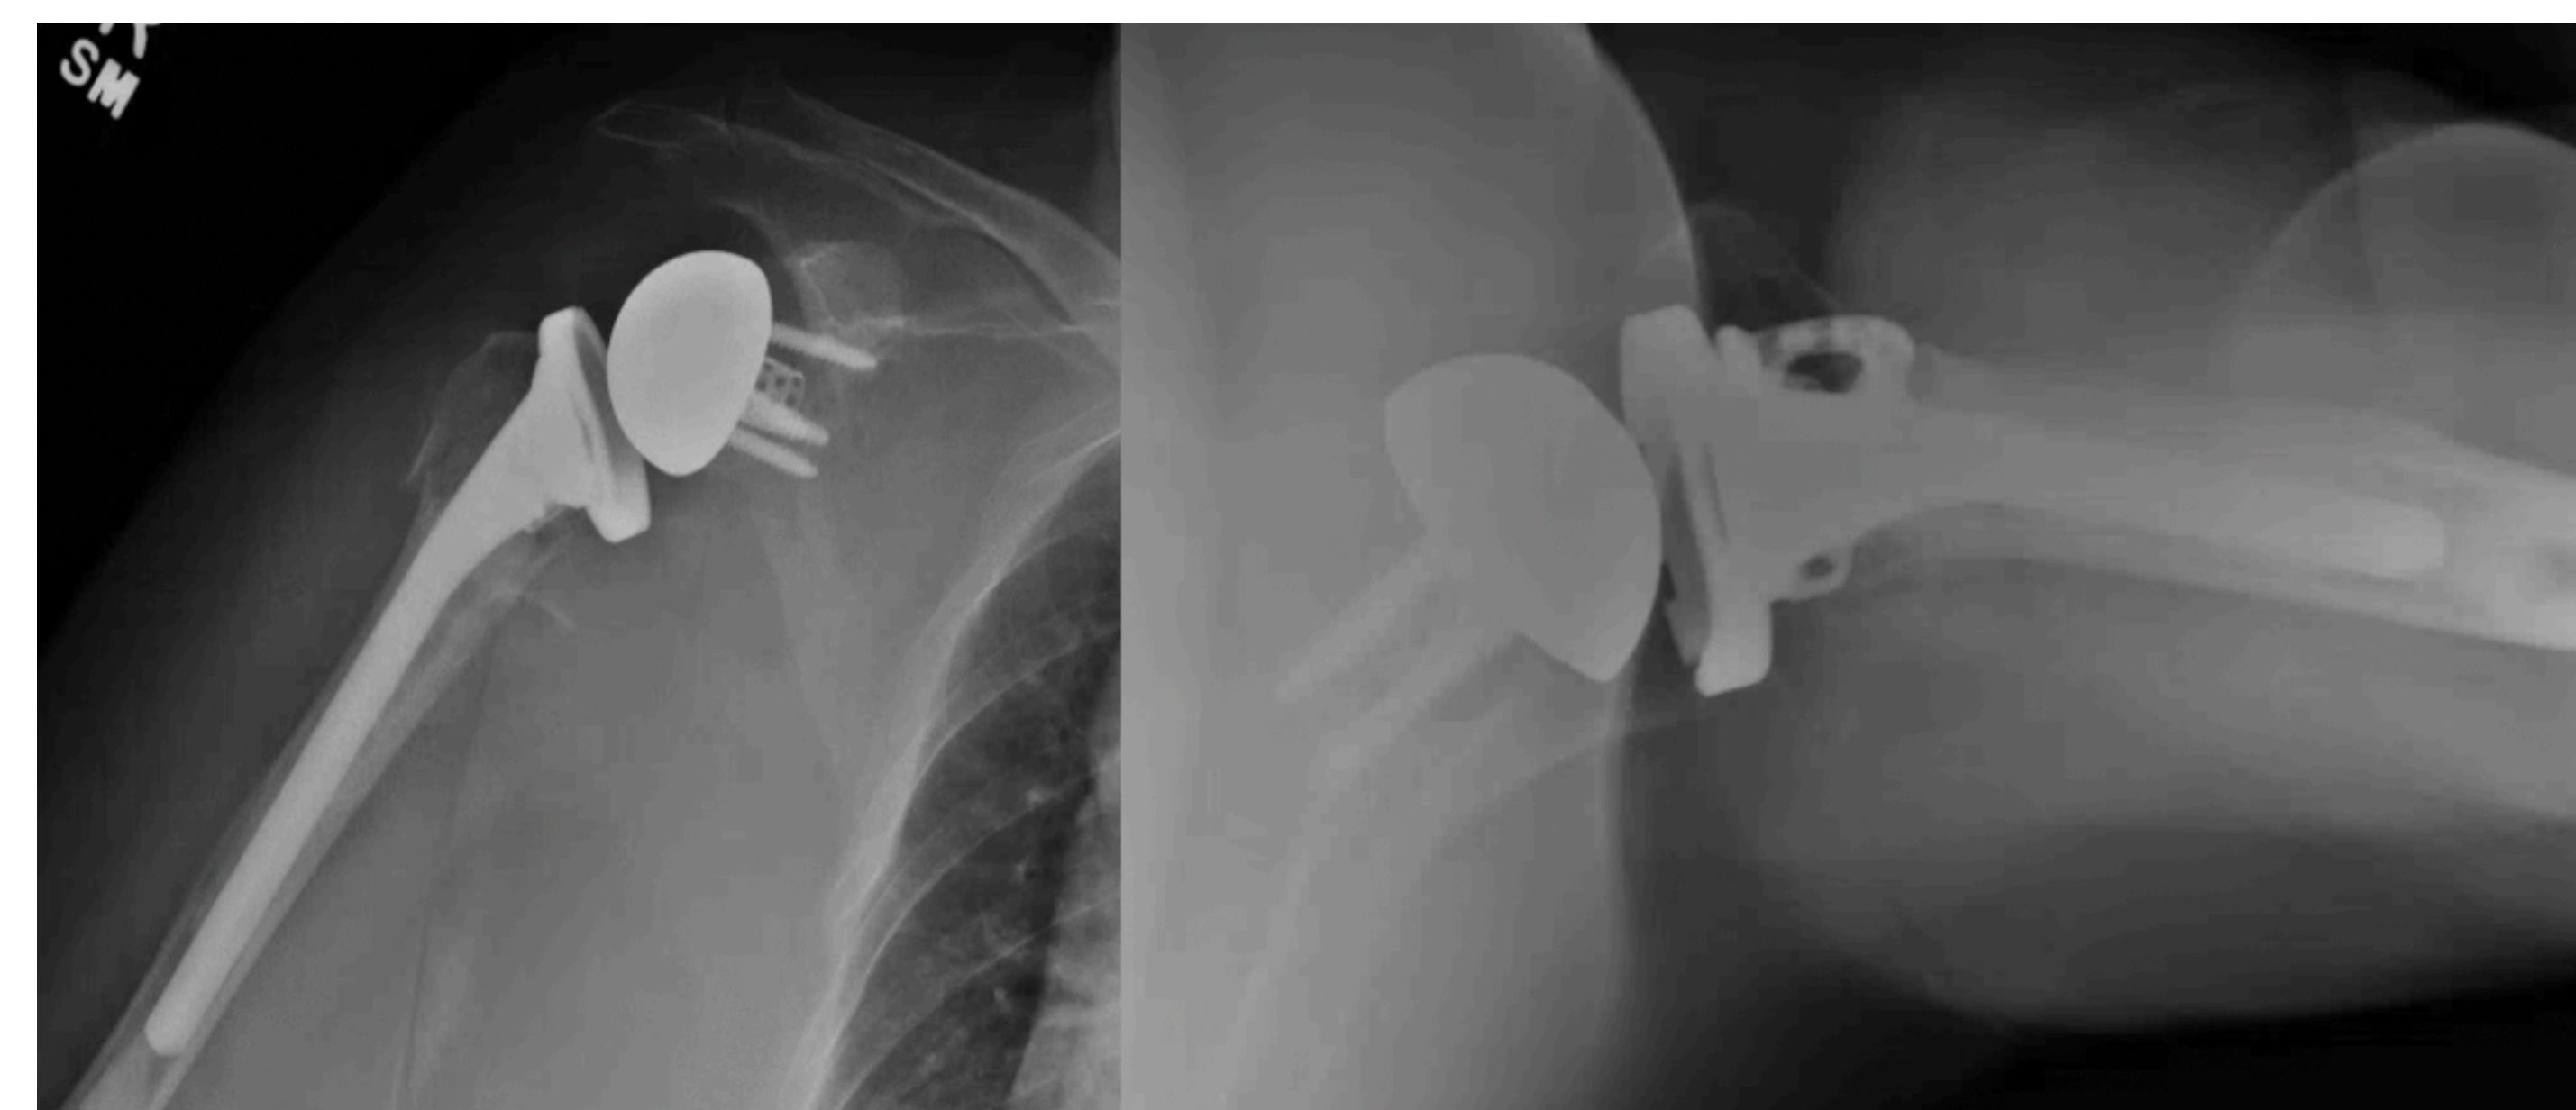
AP and axial radiographs after reverse total shoulder arthroplasty in a patient with a 3-part proximal humerus fracture.
